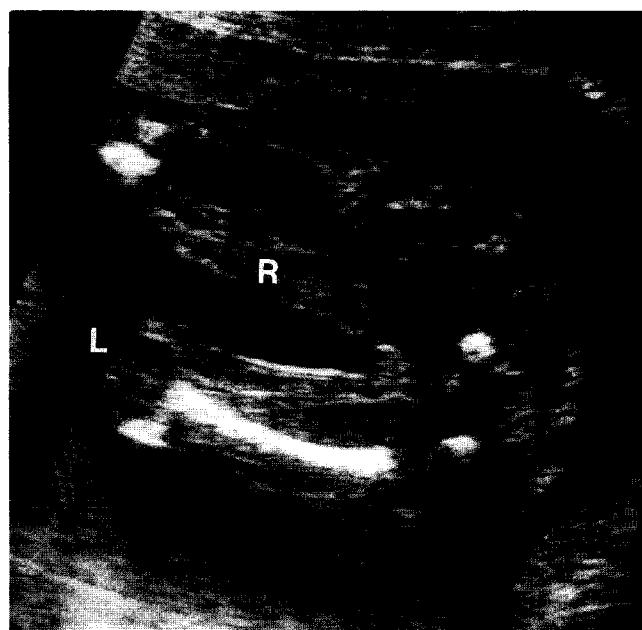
Sonogram of enlarged upper fetal right leg and irregular sized sonolucent cystic lesions extending into the buttock (R); normal left side (L)
